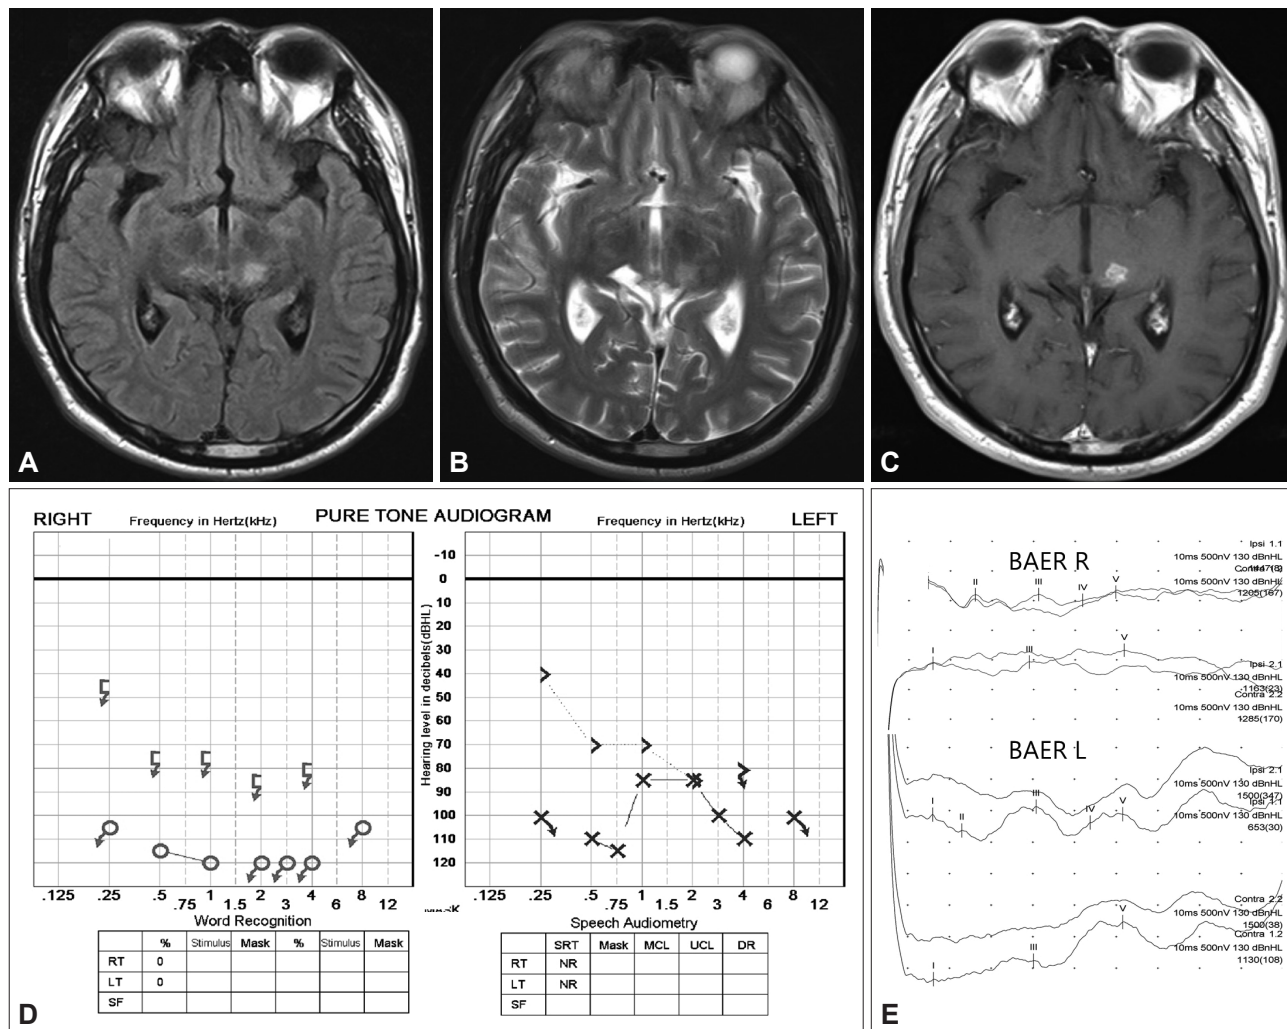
Axial brain MR images (A, B, and C), pure-tone audiogram (D), and brainstem auditory evoked response (E). A and B: FLAIR and T2-weighted images showing high signal intensities in the bilateral thalamic-midbrain junction. C: T1-weighted image showing an enhanced lesion in the left medial geniculate body, suggestive of a subacute infarction. D: Pure-tone audiometry and speech audiometry showing bilateral sensorineural hearing loss. E: The brainstem auditory evoked potentials were normal. BAER: brainstem auditory evoked response, FLAIR: fluid attenuated inversion recovery.
